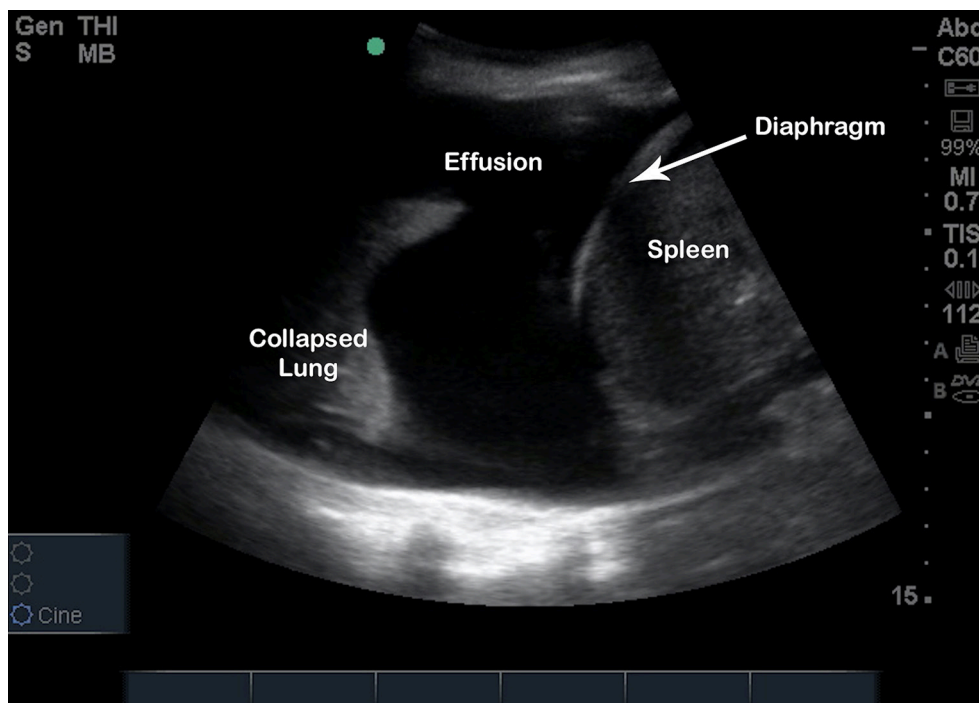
Lung ultrasound scan showing a large pleural effusion (curved array).
